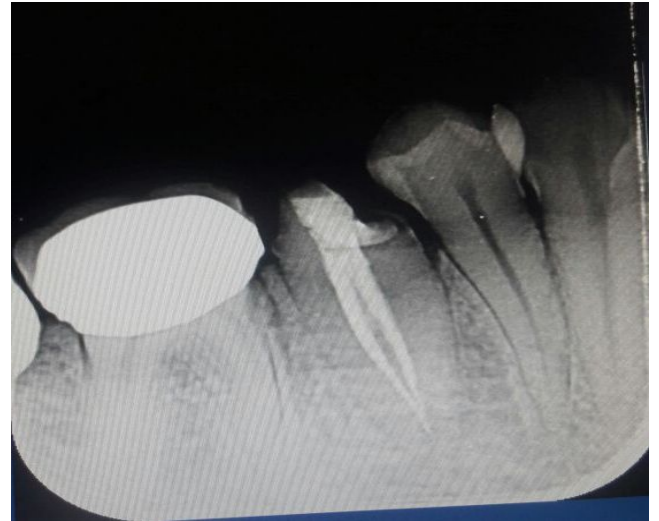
Post obturation radiographic picture
